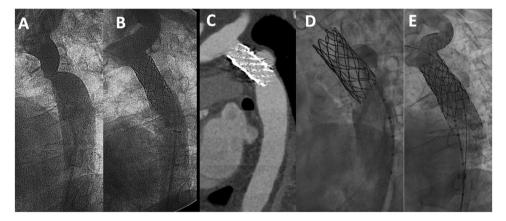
Example of late aneurysm formation evidenced 15 years after successful stent implantation. A, baseline angiography; B, immediate result; C, CT 15 years after stent implantation; D, angiography at the time of the CT; E, exclusion of the aneurysm after covered stents implantation. CT, computed tomography.
